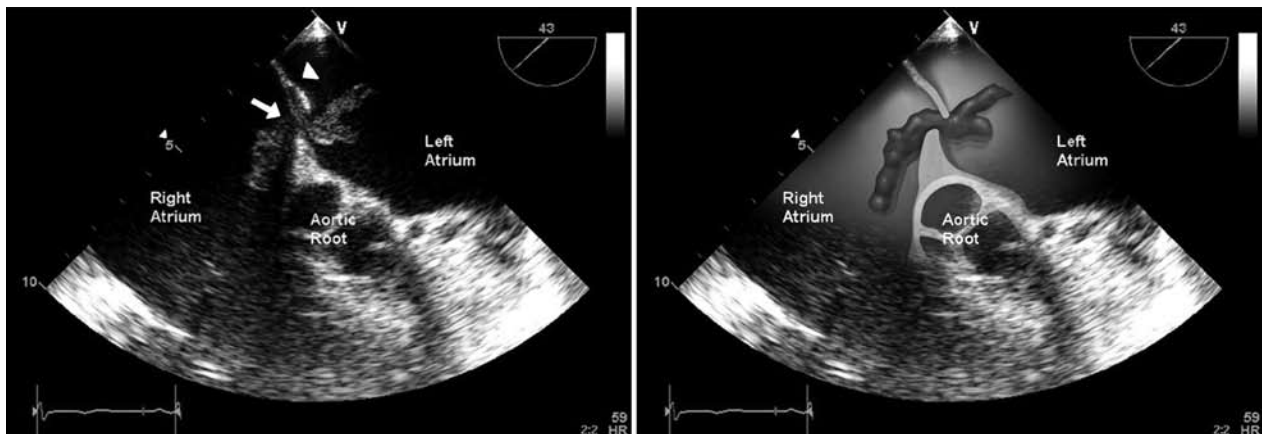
Transesophageal echocardiogram shows the septum primum (*arrowhead*) and a venous thrombi caught in transit across a patent foramen ovale (*arrow*). (Reprinted from reference 3 with permission from Elsevier.)
